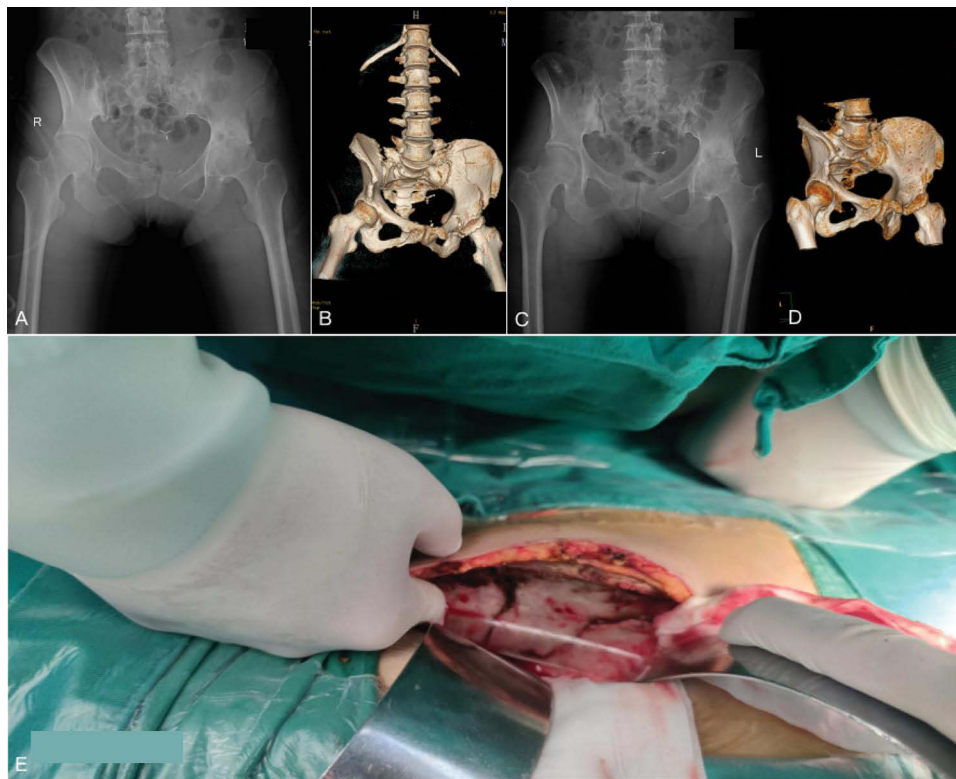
Preoperative and postoperative X-rays and CT scans of a 42-year-old female patient with a left iliac wing fracture of the pelvis. (A) shows the X-ray of the left iliac wing fracture, and (B) displays the three-dimensional-CT reconstruction. (C) is the postoperative follow-up X-ray, while (D) shows the three-dimensional-CT reconstruction at 1-year post-operation, demonstrating complete healing of the fracture line with visible screw tract holes left by absorbable screws. (E) shows intraoperative photograph showing exposure of the left iliac wing fracture site during fixation.
